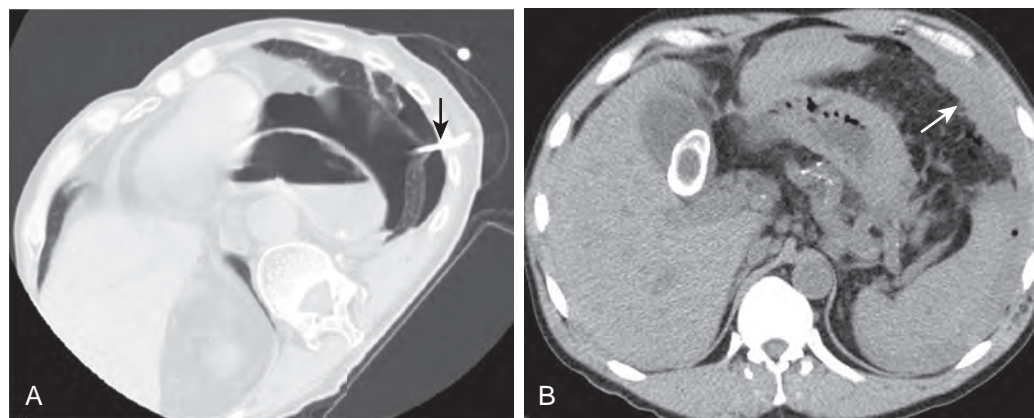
Postbiopsy complications. A. Postbiopsy CT showed a left-sided pneumothorax that was successfully managed with catheter drainage (arrow). B. Postbiopsy CT shows hemorrhage (arrow) in the left upper quadrant, which was conservatively managed.
